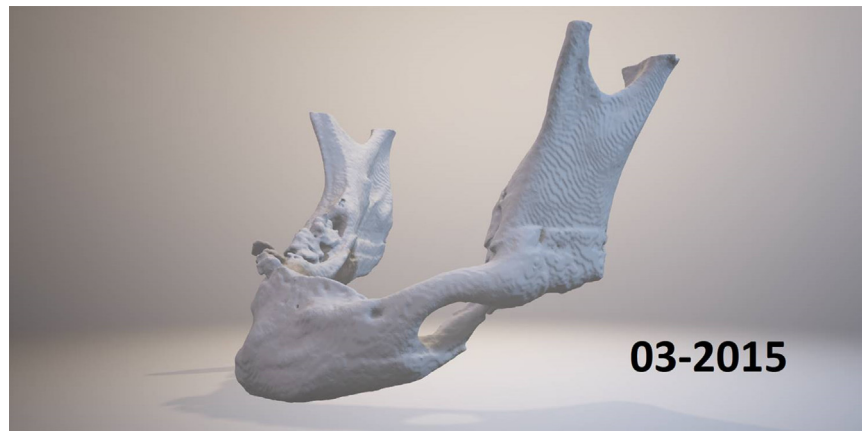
3D CT scan after 50 months of PENTOCLO treatment showing reconstruction of the crestal part of the mandible and consolidation of the fracture site.
